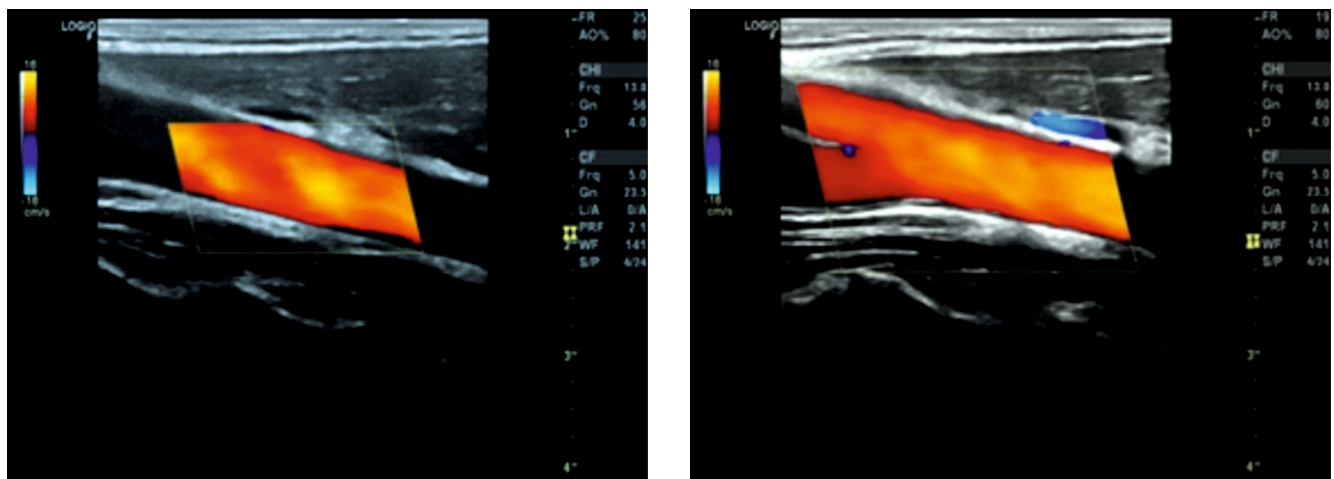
Longitudinal color Doppler mode image of the CCA (left)
